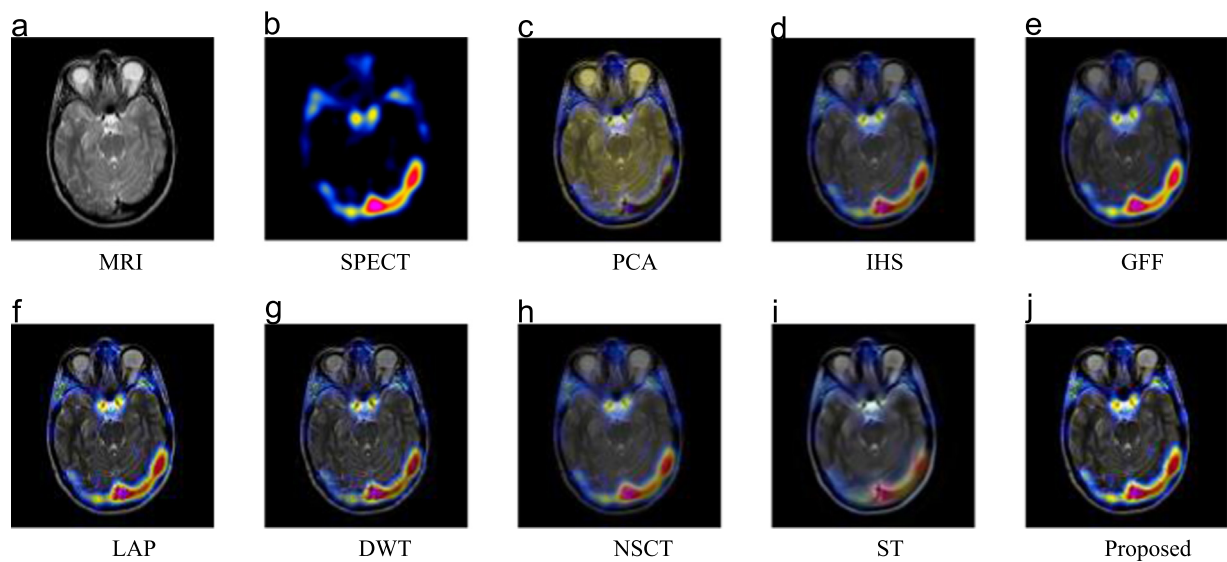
Example 1: Performance comparison of different methods on MRI-SPECT fusion.
